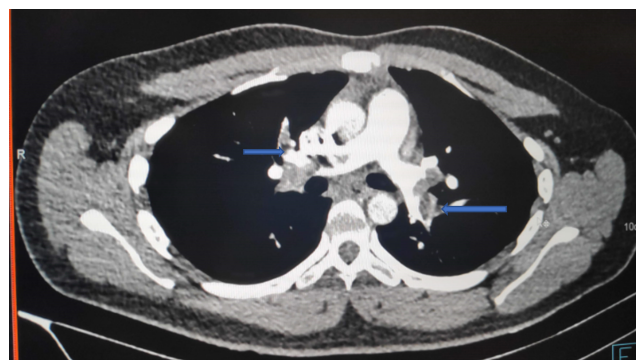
Coronal view of computed tomography pulmonary angiogram showing occluding thrombus in bilateral pulmonary vessels (blue arrows).
